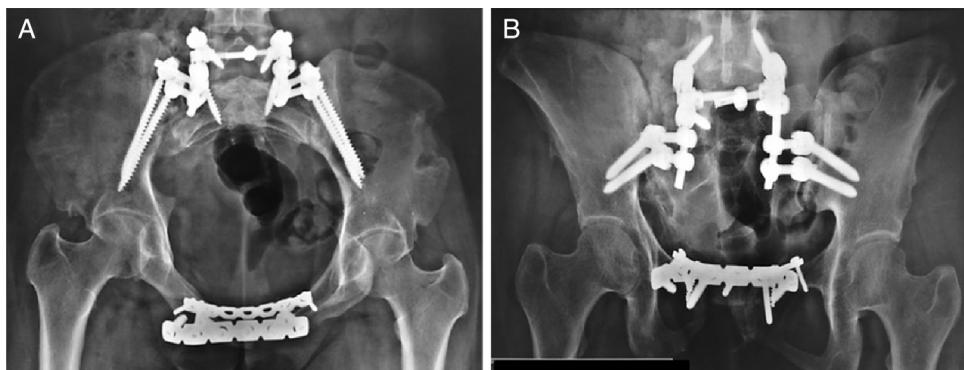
Radiographs of the first postoperative year. (A) Inlet view and (B) outlet view.
